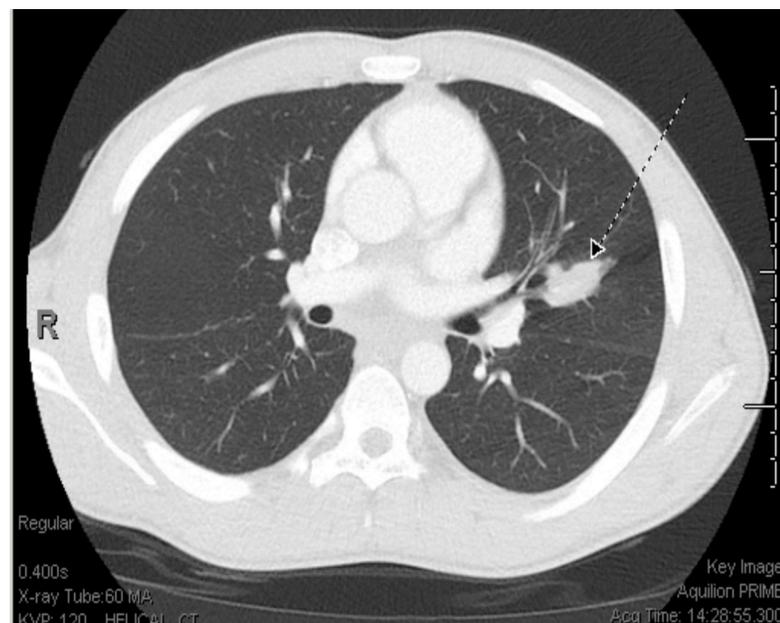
CT chest showing multiple bilateral centrilobular pulmonary nodules with an elongated lesion in the left upper lobe suggesting mucoid impaction, measuring 3.3-cm.
